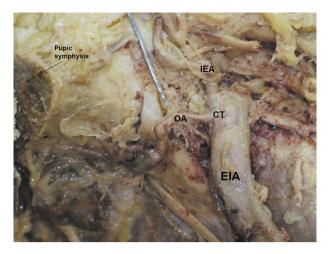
The obturator artery arising indirectly from the external iliac artery, that is, from a common trunk with the inferior epigastric artery. ElA: external iliac artery; IIA: internal iliac artery; CT: common trunk; IEA: inferior epigastric artery; OA: obturator artery.
